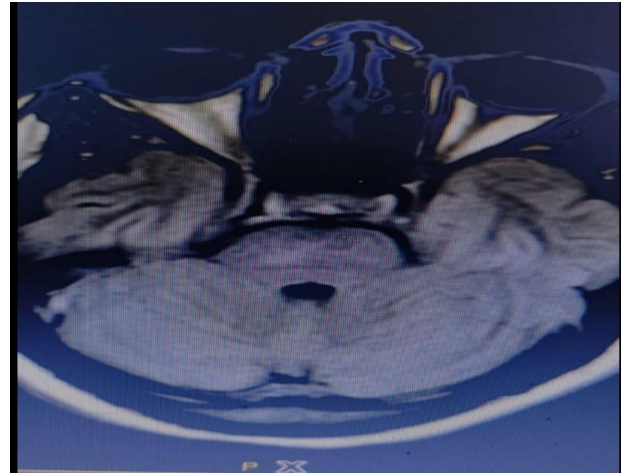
MRI showing T2 FLAIR hyperintensity in the central pons which is an incidental finding.
